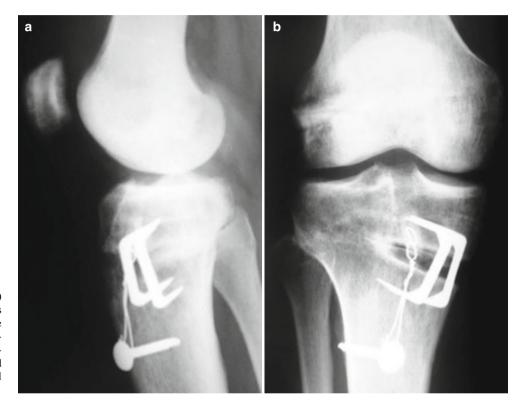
Anteroposterior (a) and lateral plain (b) radiographs demonstrating the postoperative appearance of a right knee following revision ACL reconstruction and associated opening-wedge high tibial osteotomy
